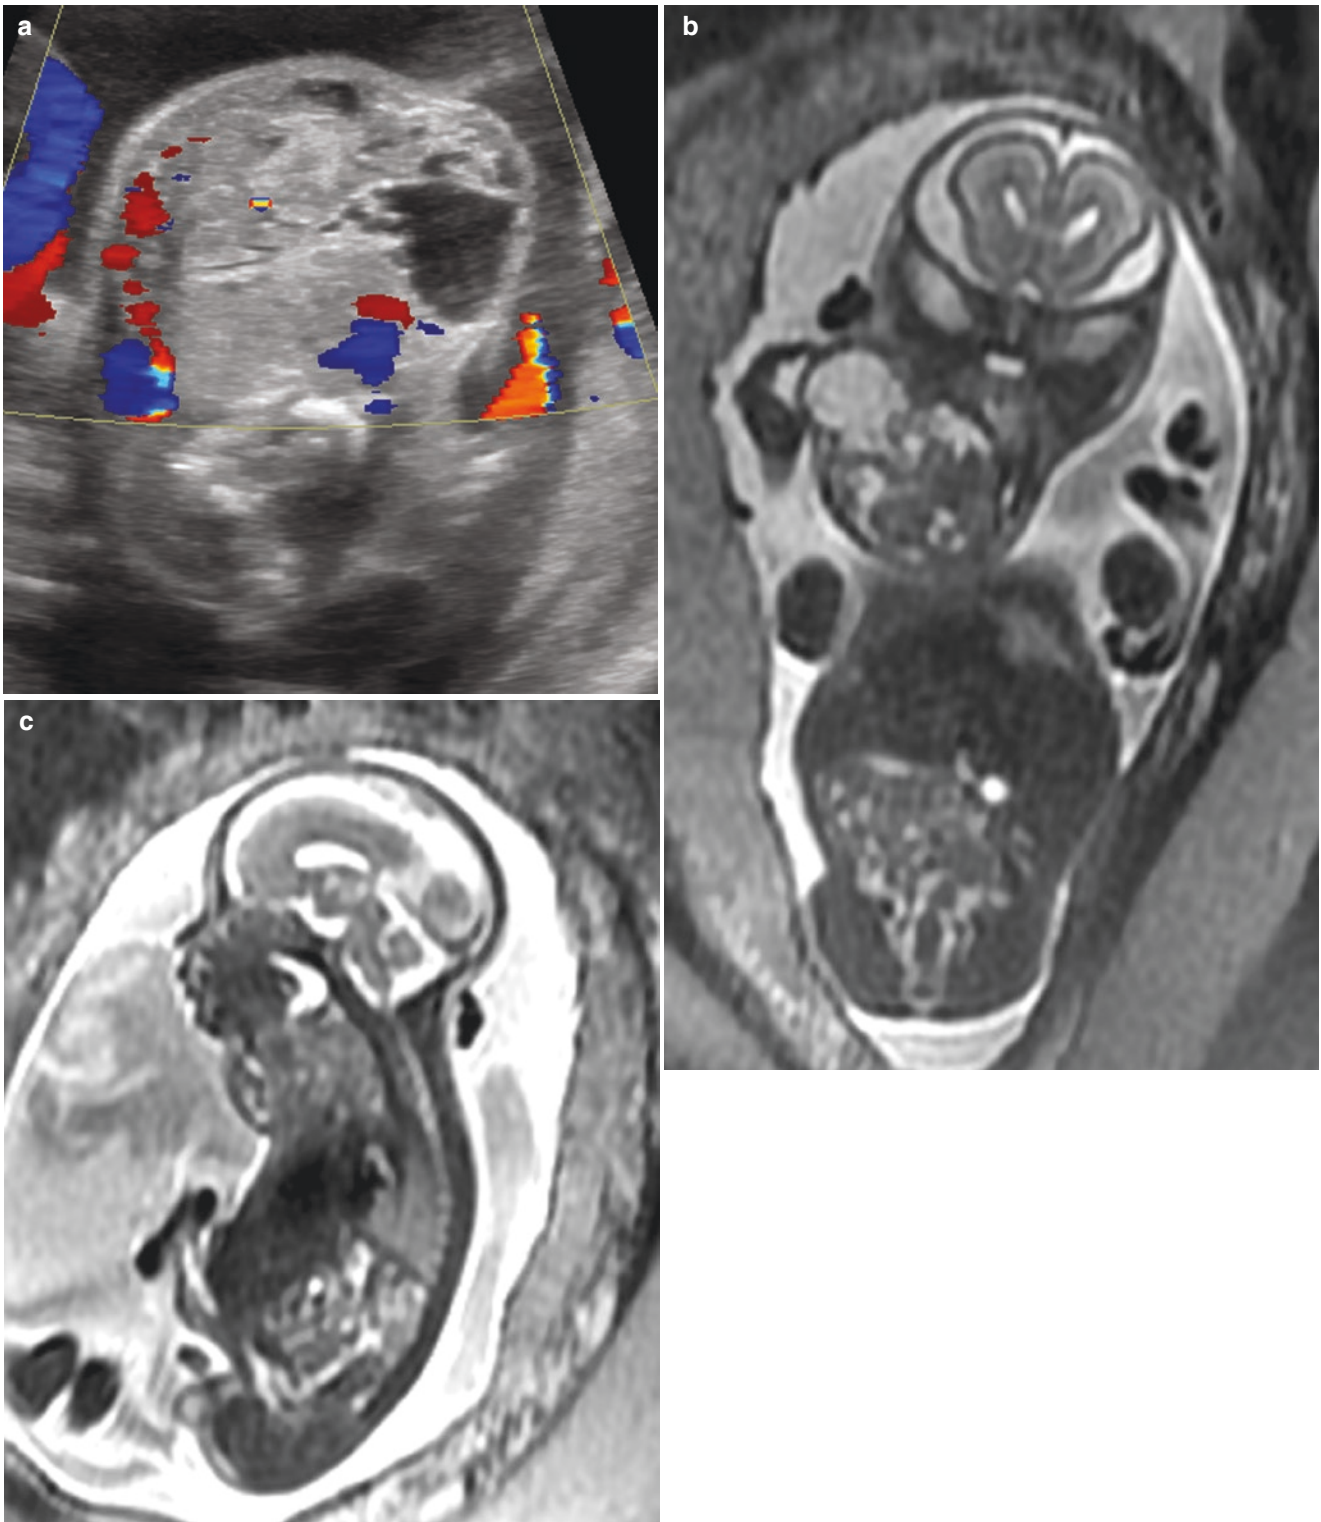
Cervical teratoma. (a) Axial US image of the fetal neck at 21 weeks' gestation demonstrates a mixed cystic and solid mass with prominent vessels. Coronal (b) and sagittal (c) fetal T2w MR images
